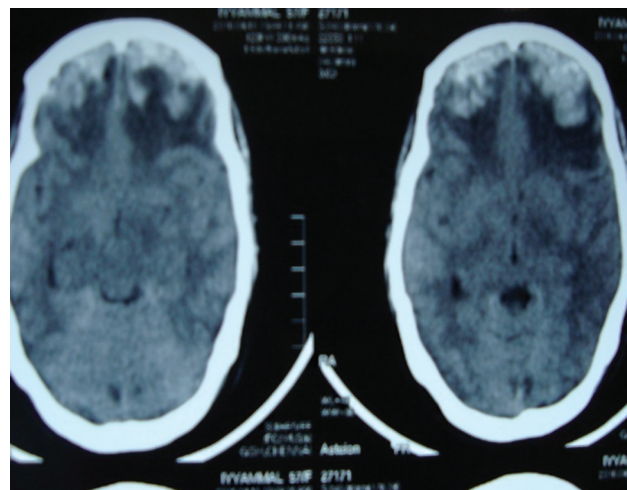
Same patient's computed tomography scan after deterioration at 15 hours showing progression of bifrontal contusions and edema.
